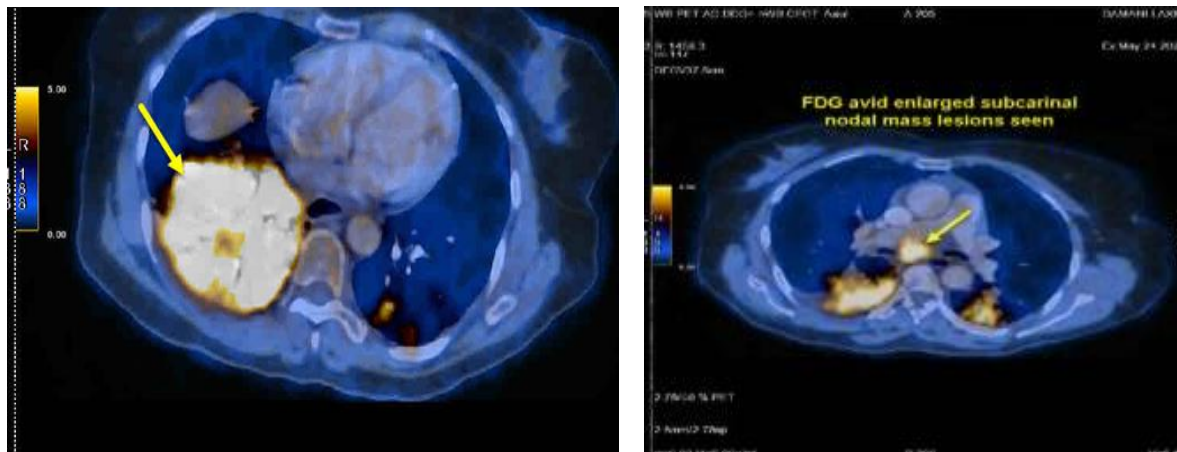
PET-CT scan of chest on May 2023 showing FDG-avid large consolidation-like lesions in the right lower lobe, multiple opacities in the right upper and left lower lobes, and FDG-avid enlarged lymph nodes
